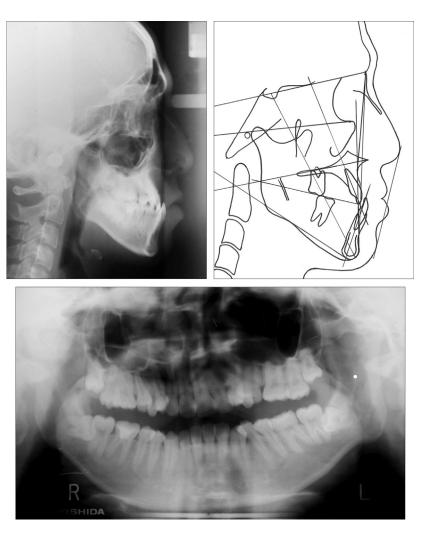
Initial lateral cephalometric radiograph, tracing, and panoramic radiograph.
